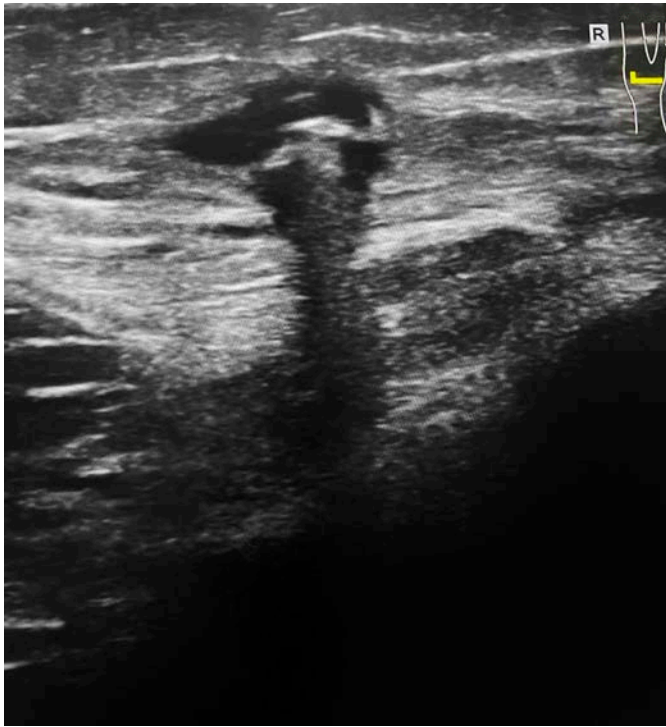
Ultrasound examination revealing the foreign body with local thrombosis of the great saphenous vein and posterior acoustic shadowing
